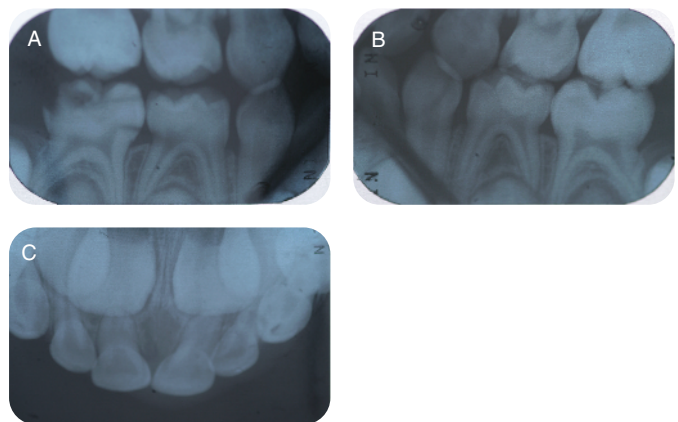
Pre-op radiographs. A. Right bitewing radiograph, B. Left bitewing radiograph, C. Maxillary occlusal radiograph
